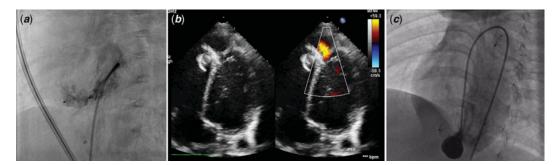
(a) Left ventriculography showing the Amplatzer ductal occluder II device closing the ventricular septal defect and minimal residual shunt proximal to the device. (b) Echocardiography showing an apical left ventricular pseudoaneurysm adjacent to the Amplatzer septal occluder device. (c) Left ventriculography showing the pseudoaneurysm.
